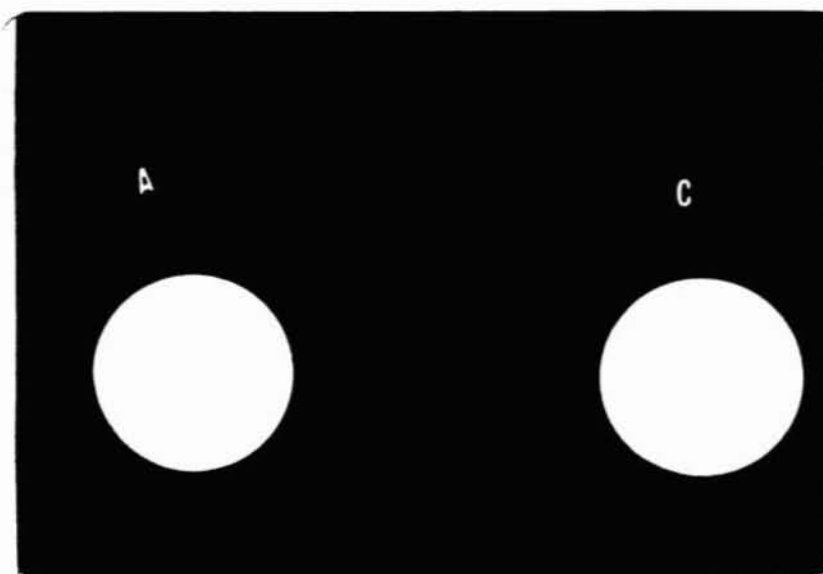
X-ray film of NR vulcanizates containing 100phr precipitated zinc oxides
